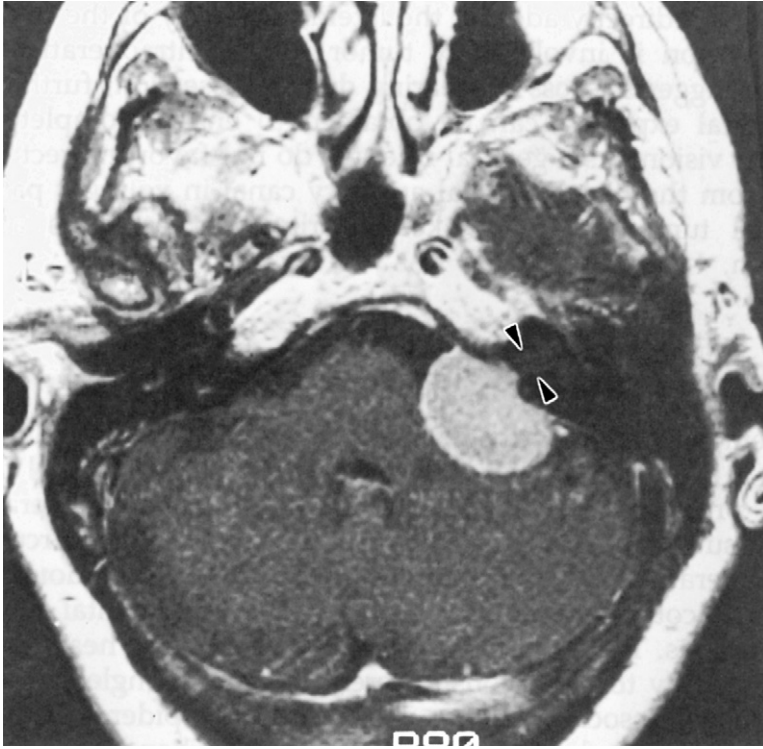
An atypical medium-sized acoustic neuroma on a gadolinium-enhanced MRI scan demonstrating no extension into the internal auditory canal (*arrowheads*). When useful hearing remains in a wholly extracanalicular tumor, even though it is relatively large, the authors recommend a suboccipital hearing conservation approach.
